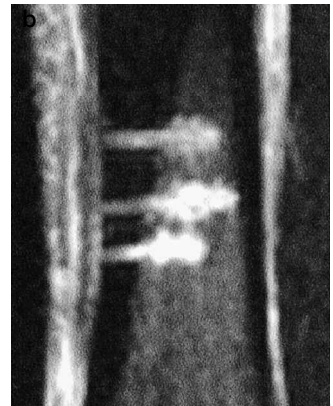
A 34-year-old female hurdle runner who complained of mid tibial pain which did not respond to several types of conservative treatment (a). The site of chronic bone edema was seen with MRI and then successfully treated by drilling (b).
